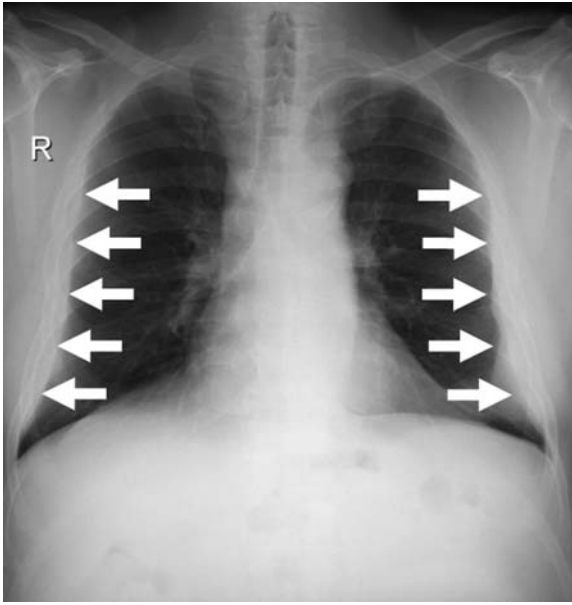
Postero-anterior chest radiograph shows extrapleural symmetric and smooth fat pads, with wavy contours, mimicking pleural thickening (arrows)
